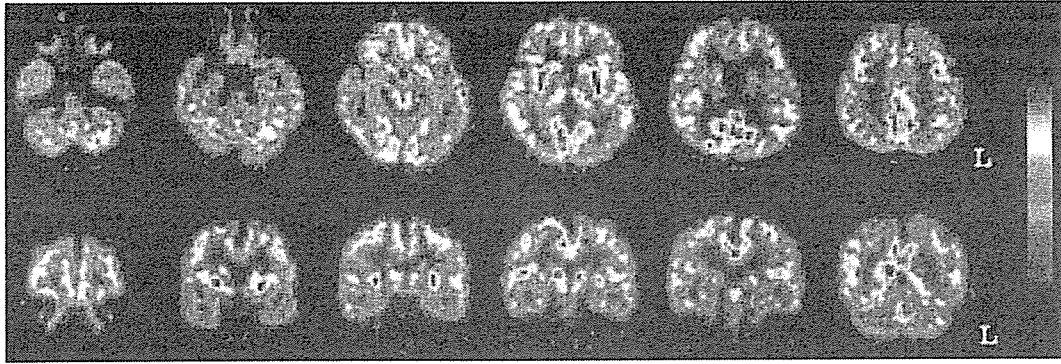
[F-18] FDG PET shows hypometabolism in the frontal and parietal cortices, but metabolism in the striatum is well preserved.
